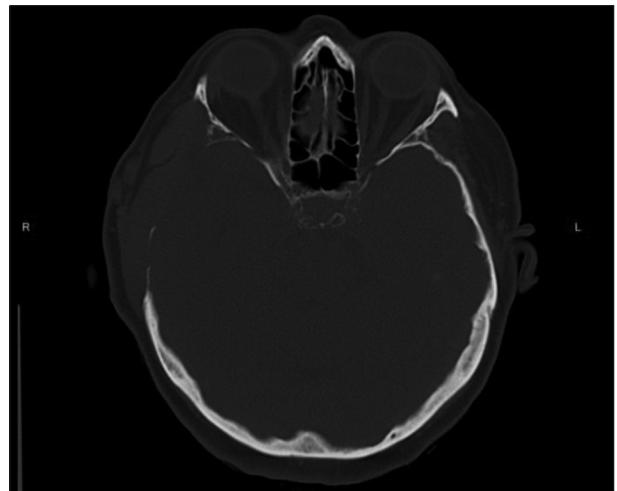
Bone window CT scan proved the lack of temporal bone on the right side
